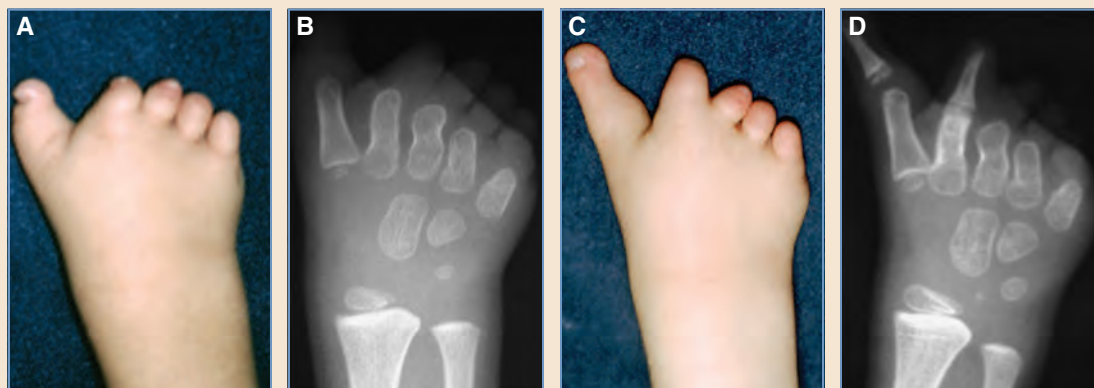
Thumb in symbrachydactyly. A and B, The left hand and radiograph of a patient with generous soft tissue nubbins, which represent the thumb and digits. C and D, He was an ideal candidate for nonvascularized toe phalangeal transfer to the thumb and index rays. The first web space was also deepened and widened with local flaps. Despite the limited mobility, this reconstruction is very functional as a helper hand.
